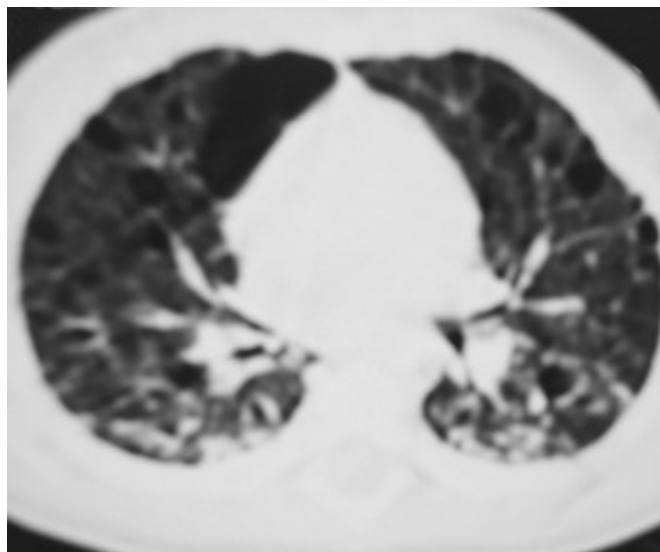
Chest CT scan shows diffuse parenchymal nodules with air-filled cysts, paraseptal bullae, and bilateral pneumothoraces.
